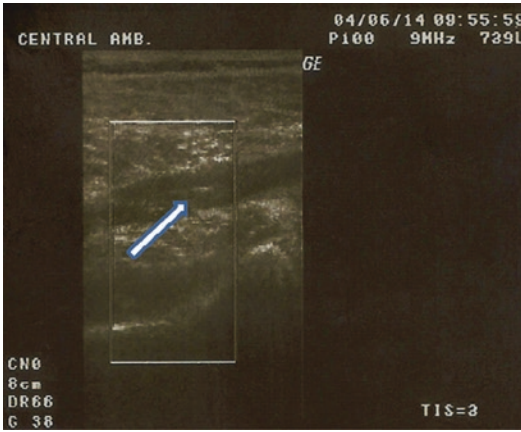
Echo Doppler of lower limbs showing dilated right femoral veins, with spontaneous contrast: right popliteal vein: thrombus 80% occlusion
